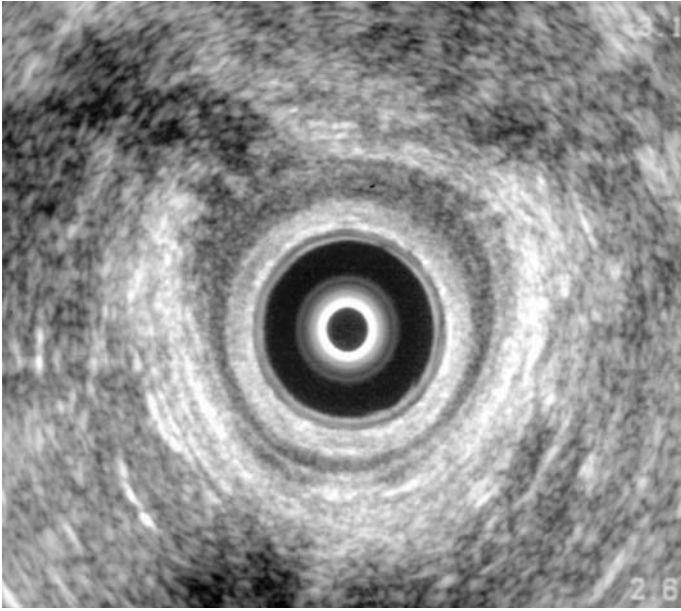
Endo-anal ultrasound demonstration of external sphincter defect.
